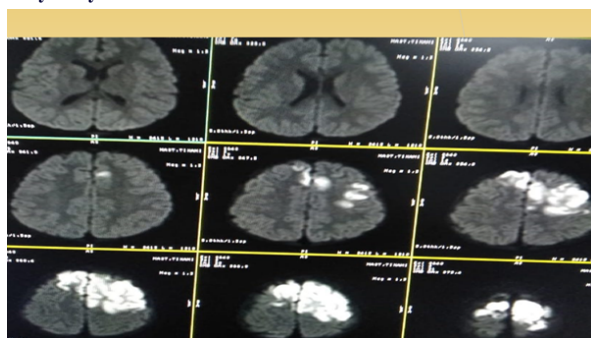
6year male child presented with recurrent episode of seizure with weakness of right side of body. MRI showed diffusion restriction in bilateral frontal lobe. Later Computed tomography angiography was done showing stenosis in bilateral ICA, ACA and MCA territory
